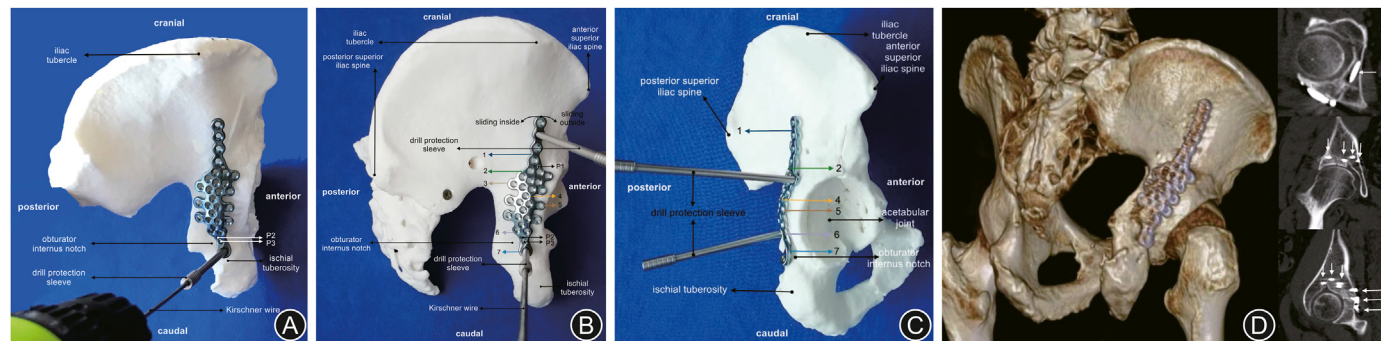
Plate implantation in pelvis. (A) Kirschner wire was inserted in the caudal end of the plate (the 7th zone) by the drill protection sleeve. (B) Fix the caudal end of the plate so that the cranial end can slide inside or outside (indicated by the arrow) for the best position. (C) Side view shows that the plate curvature matches the posterior surface of the acetabulum. (D) Pelvic CT shows that the plate is in proper position, and the screw distribution is reasonable in transverse, coronal and sagittal plane. Note: Vertical arrows indicate screws of zone 2; horizontal arrows indicate screws of zone 3 and zone 4.
